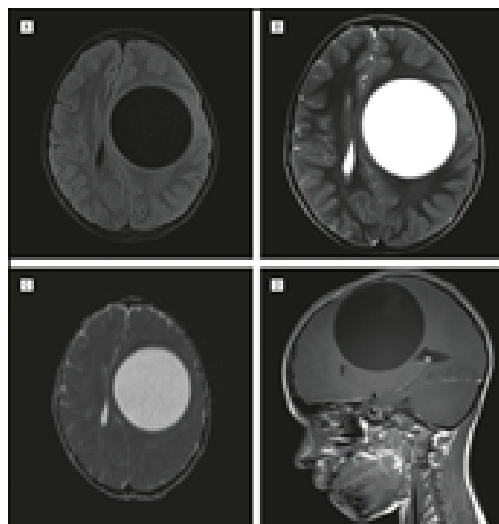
MRI brain T1,T2 axial & sagittal section
